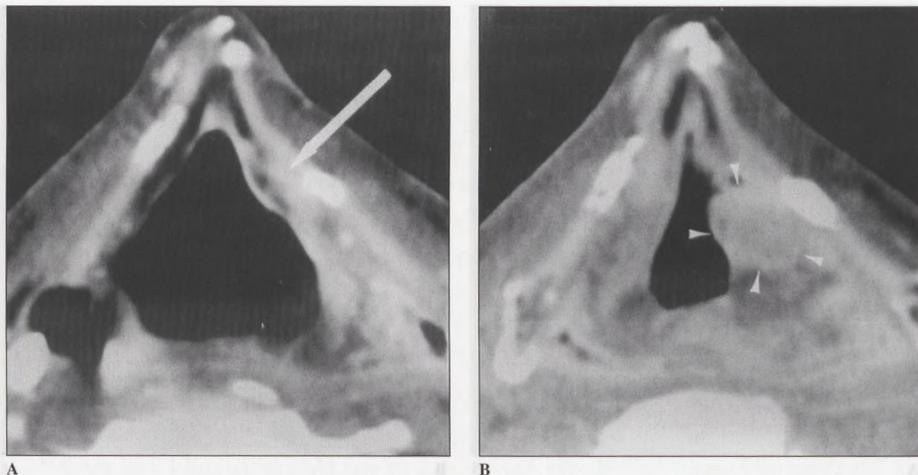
CT images of a patient with a T3 carcinoma of the left true vocal cord and a high pretreatment risk profile. A. Pretreatment CT image just above the false cord level demonstrates involvement of the left aryepiglottic fold and obliteration of the paraglottic space (arrows). B. CT image at the same level, obtained at 3 months post-RT. A focal mass, in the left aryepiglottic fold, with a maximal diameter slightly over 1 cm (arrowheads) has developed; post-RT CT-score 3. Salvage laryngectomy confirmed the presence of local recurrence. The patient is alive without evidence of disease 2 years, 3 months after the operation. Figure 3A, reprinted with permission.¹⁰
